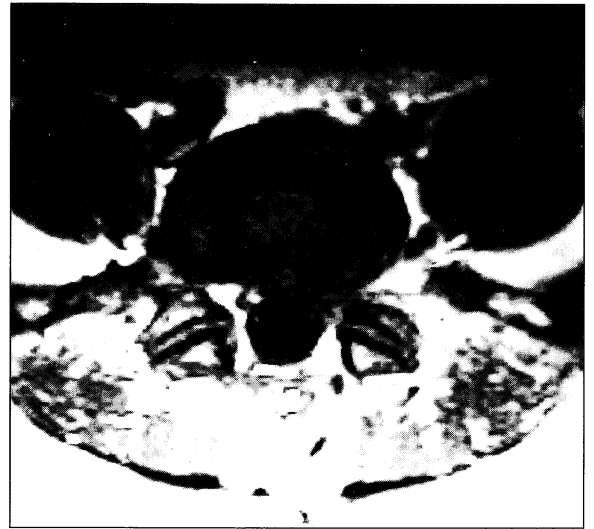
Axial T1-weighted scan shows the lesion on the left side of the spinal canal
